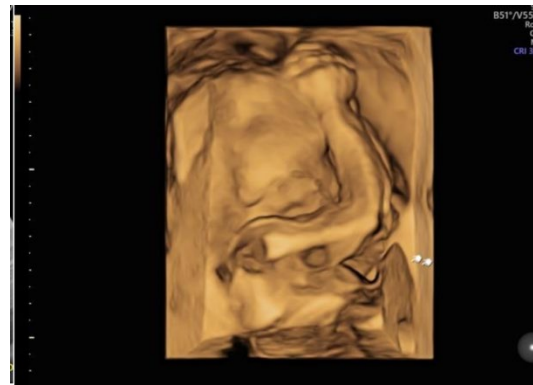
Case presentation. Upper left: omphalocele as seen on ultrasonographic screening; upper right: three-dimensional reconstruction of anterior abdominal wall defect; lower left: neonate showing large omphalocele; lower right: neonate approximately one month after successful repair of omphalocele
